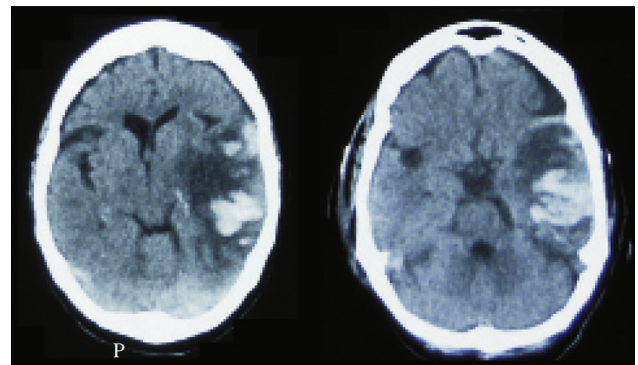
Repeated CT brain showing progression of temporal contusion with significant mass effect causing effacement of left lateral ventricle and midline shift.
